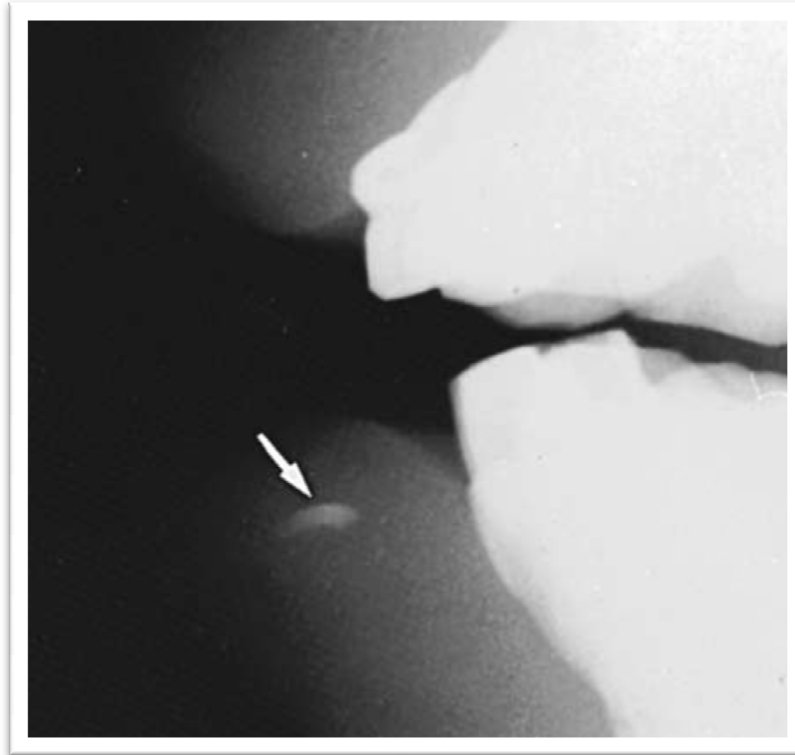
Lateral view radiograph showing a fractured tooth segment embedded in the lower lip
